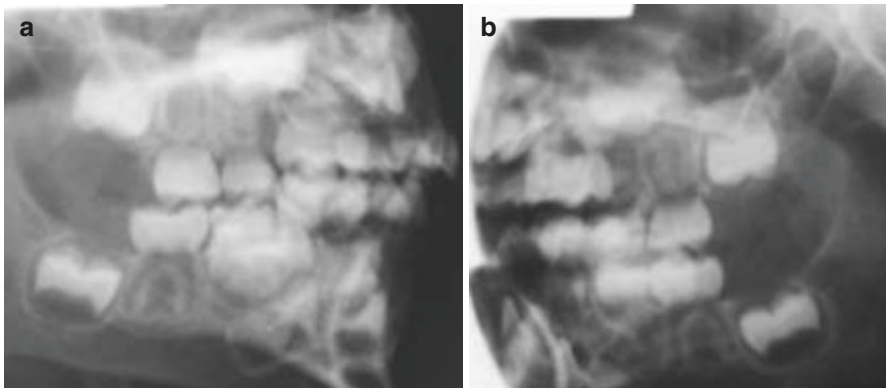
(a, b) Lateral oblique radiographs showing patient with DD type I (rootless teeth)
